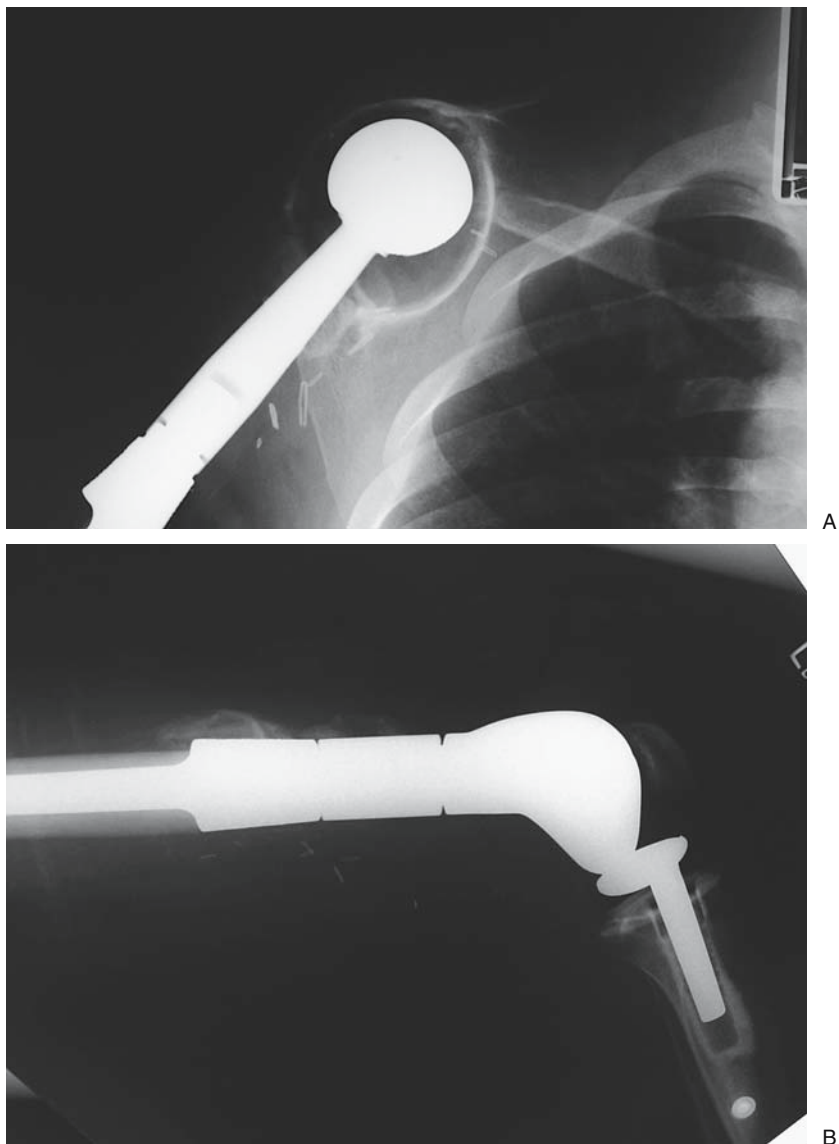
Segmental prostheses. (A) AP postoperative radiograph of a patient who underwent limb-sparing resection for osteosarcoma of the proximal humerus. A segmental prosthesis was inserted for reconstruction of the bony defect. Reconstruction with a segmental system provides better mobilization and improved function when compared with patients who have no reconstruction and are left with a flail extremity. The shoulder is the third most common site for bone sarcomas. (B) Segmental prosthesis of the distal femur. Lateral radiograph shows flexion of the knee following distal femoral resection and reconstruction with a modular segmental prosthesis. The distal femur is the most common site for bone sarcomas (osteosarcoma) to arise. The technique of reconstruction with a prosthesis is referred to as limb-sparing surgery, in lieu of an amputation.
